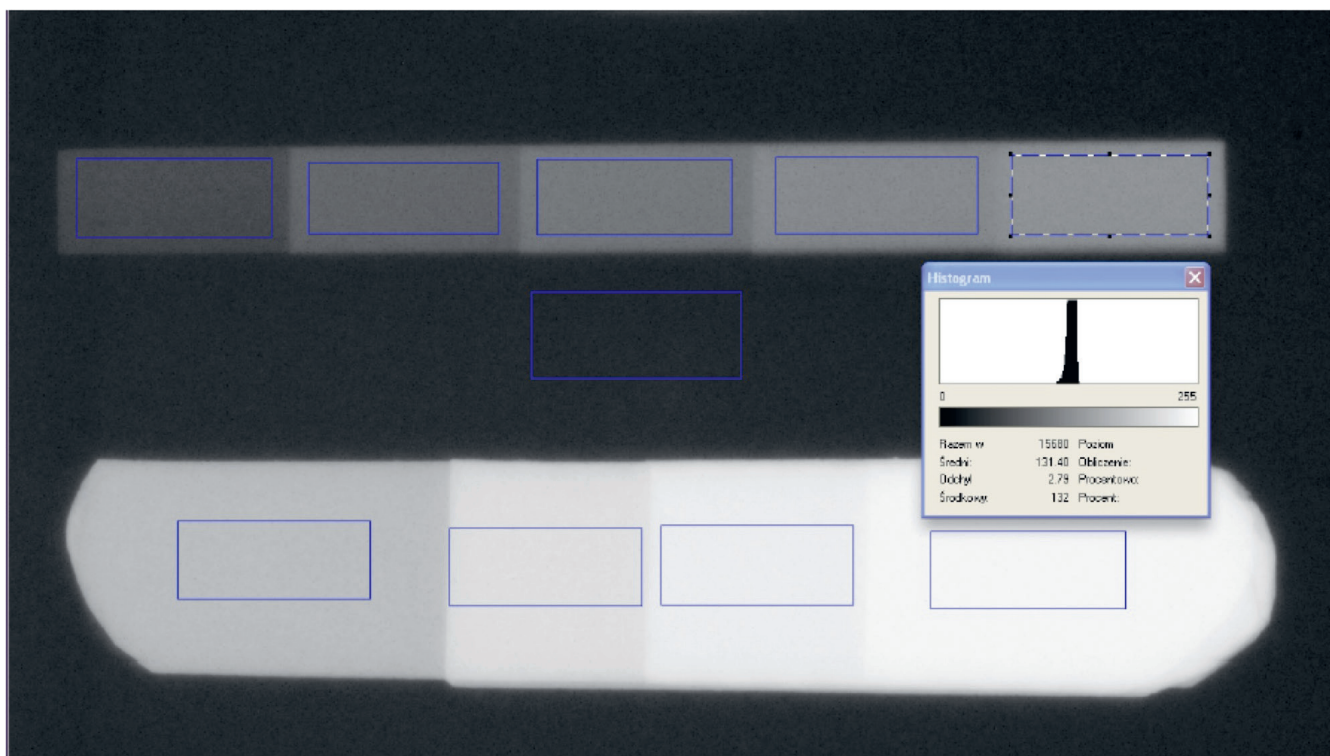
The analyzed radiograph with the marked region of interest (ROI) and histogram of optical density
